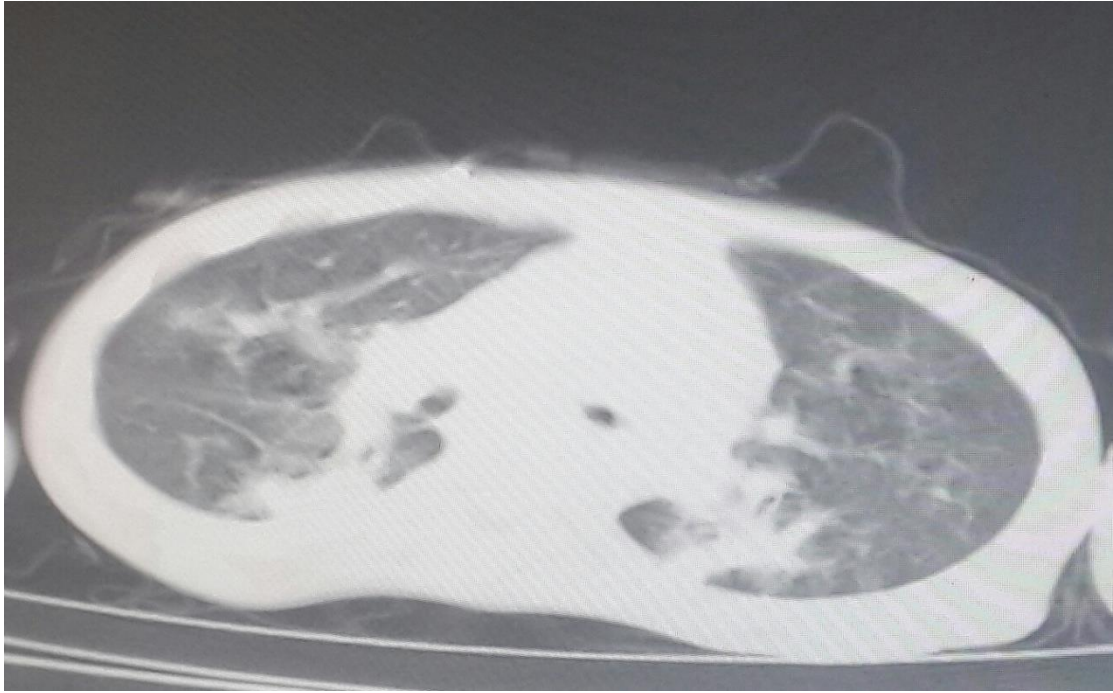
CT chest for female 6 year old consolidation and pneumonia
